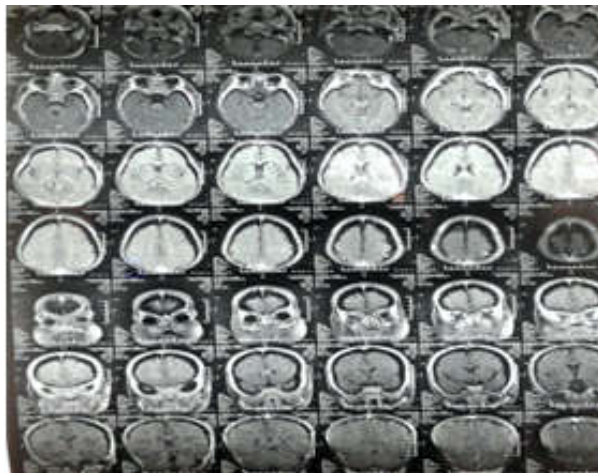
MRI showing benign enlargement of subarachnoid space
